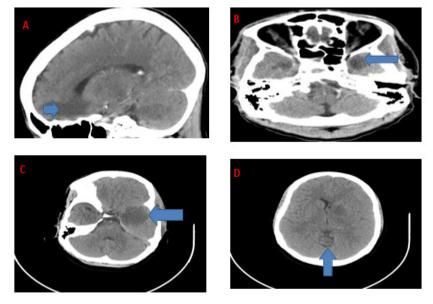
(A,B): CT-scan of the brain studies highlighting areas of infarction of the frontal and temporal lobes in case 1; (C): The presence of thrombophlebitis of the cavernous sinus; (D): An intracranial extension in case 2.
